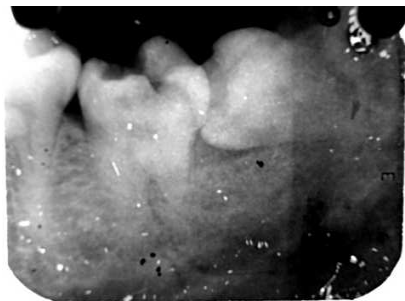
Radiograph showing the double PDL spaces in the distal root
